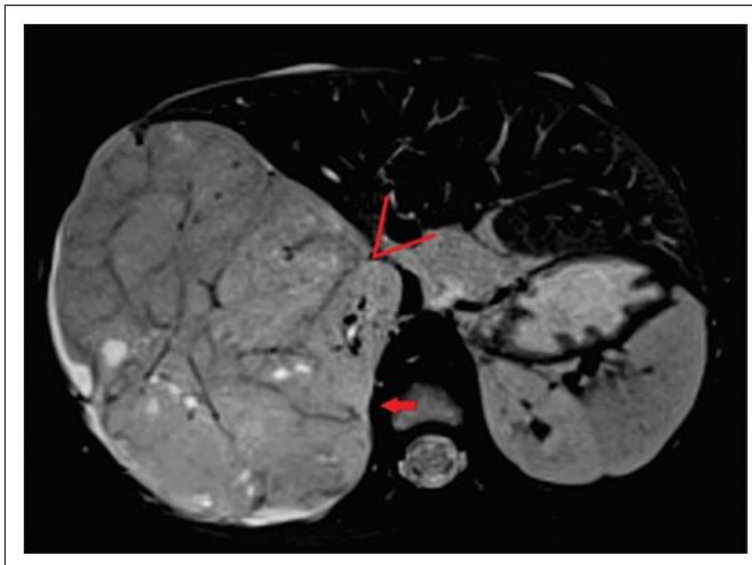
Axial fat-suppressed T2-weighted magnetic resonance image of a large nephroblastoma arising from the inferior pole of right kidney. The claw sign is positive at the posterior kidney–tumour interface (red arrow). However, there is infolding and an acute angle at the anterior kidney–tumour interface (red marker). In conflicting cases, a positive claw sign was diagnosed.
